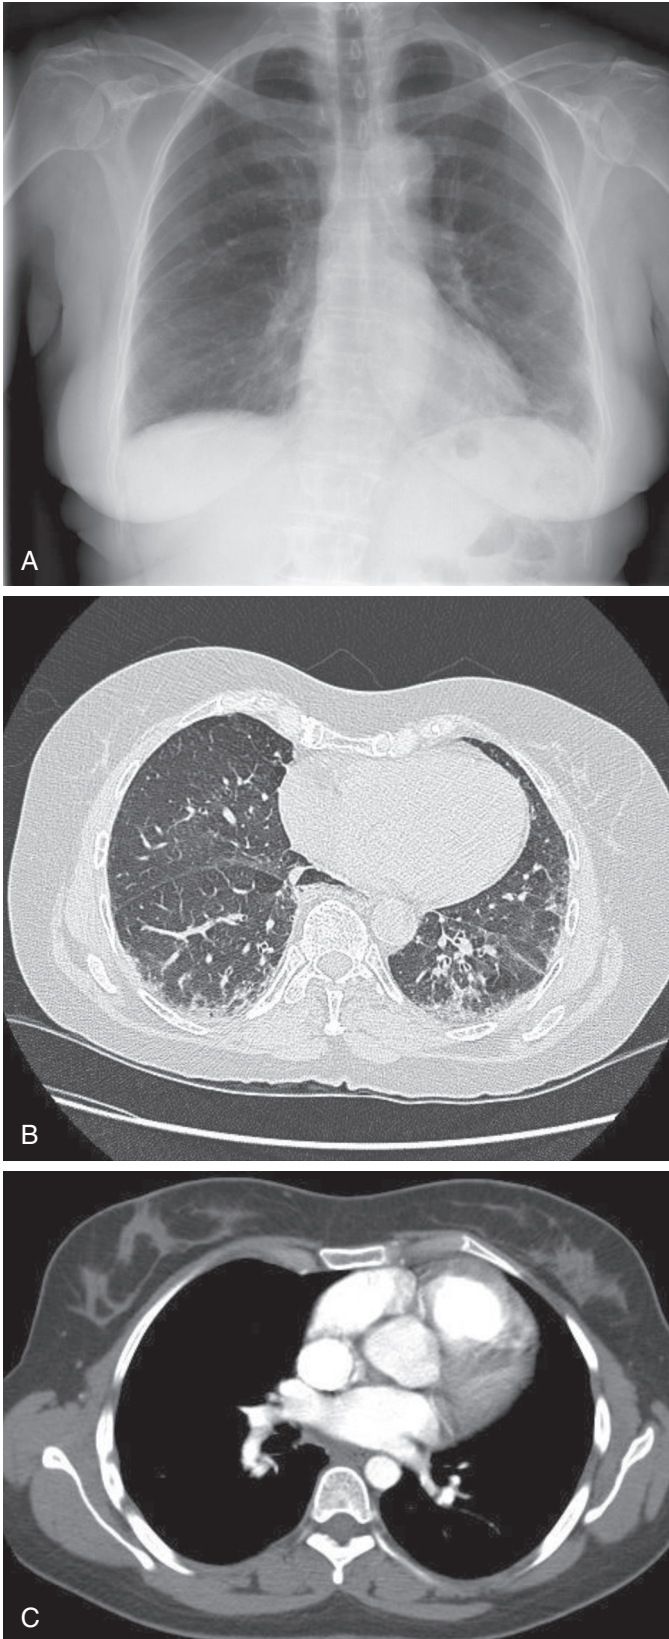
SSc. A, Chest radiograph of a patient with dSSc showing interstitial shadowing, mainly in the lung bases, along with associated loss of volume, consistent with early pulmonary fibrosis. B, CT of the thorax demonstrating ground-glass opacity, subpleural honeycombing with thickening of the interlobular septa, and linear fibrotic bands, in keeping with pulmonary fibrosis. There is also evidence of associated mild traction bronchiectasis. C, Pulmonary CTA in a patient with limited cutaneous scleroderma and pulmonary hypertension. The right atrium and right ventricle are enlarged, and there is dilation of the pulmonary trunk.
